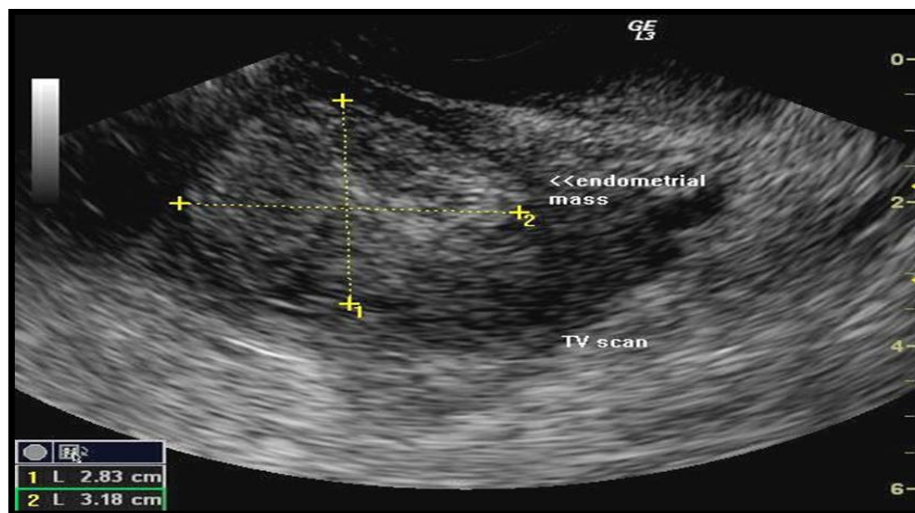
Transvaginal sonography of the uterus in postmenopausal patient showed carcinoma of the endometrium (adenocarcinoma).
